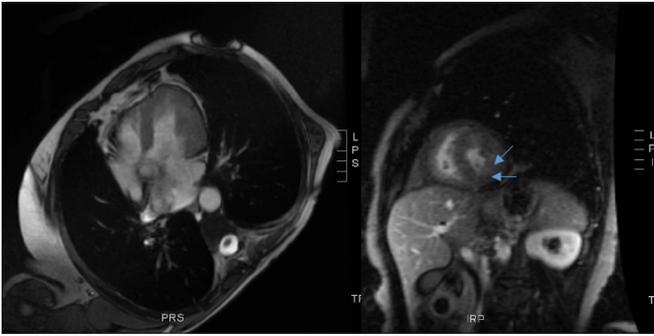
Cardiac MRI revealed concentric LVH with septal thickening. There was delayed enhancement (arrowed) with speckling in the inferolateral and anteroseptal regions.
